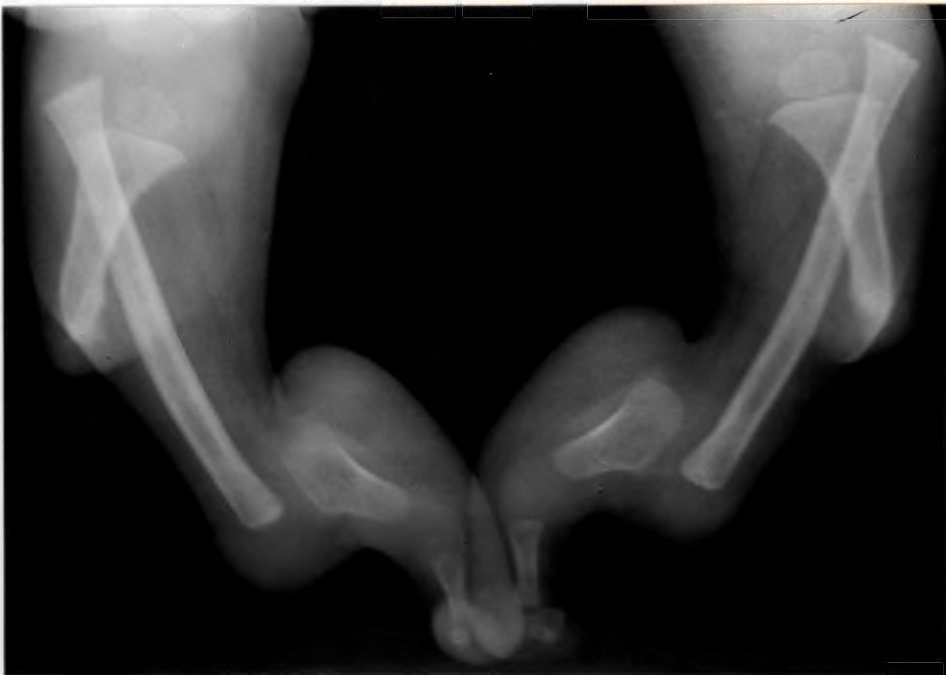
Radiograph of the lower limbs of IV-I: Bilateral, severe malformations are present.
